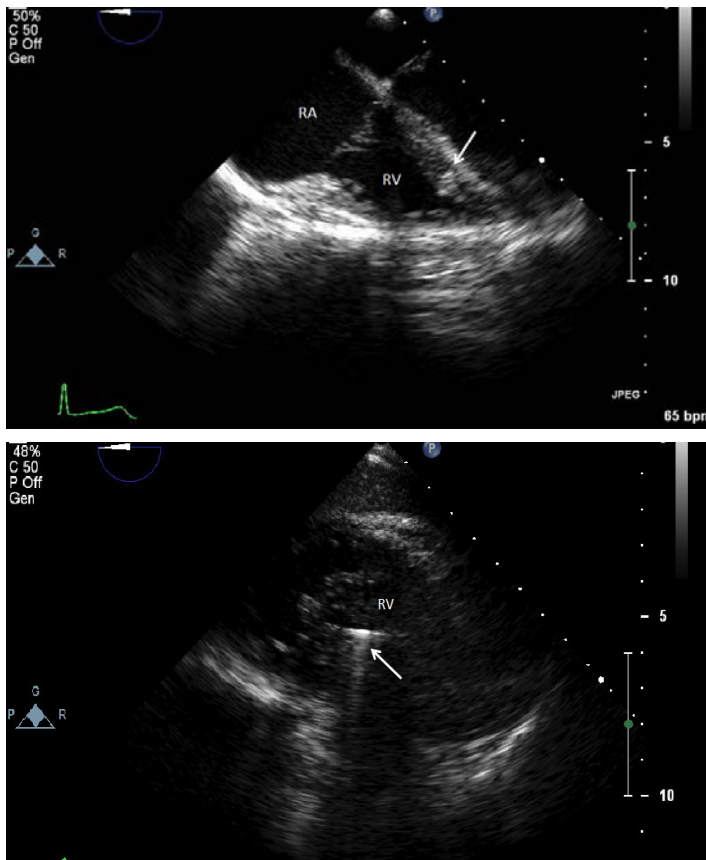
Transesophageal echocardiogram views of right ventricular (RV) apical view (Figure 3a [top]; arrow as bullet tip in RV trabeculae) and RV transverse view (Figure 3b [bottom]; arrow as bullet demonstrating significant comet tail artifact).
